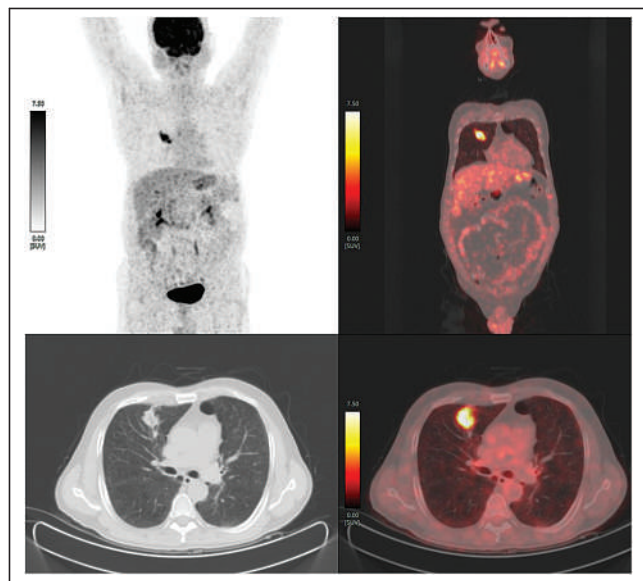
^{18}F -FDG PET/CT after 2 cycles of peptide-receptor radionuclide therapy (upper left: maximum-intensity projection image; upper right: fused coronal; lower left: transaxial CT; and lower right: fused transaxial) showing ^{18}F -FDG-concentrating (SUV_{max} , 9.6) ill-defined opacity in upper lobe of right lung.
